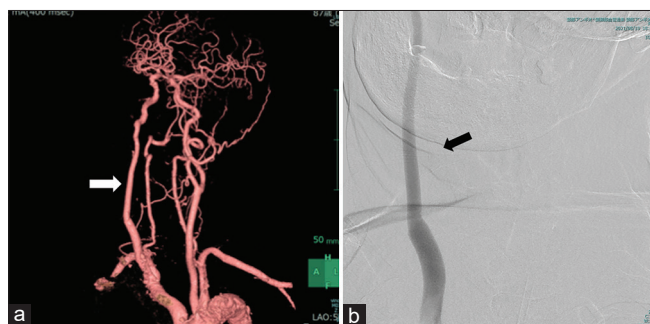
Follow up images after surgery. (a) The reconstructed 3D CTA image taken on the day following surgery showing patency of the graft (arrow). (b) DSA taken 35 days after surgery showing patency of the graft (arrow). CTA: Computed tomography angiography, DSA: Digital subtraction angiography.
